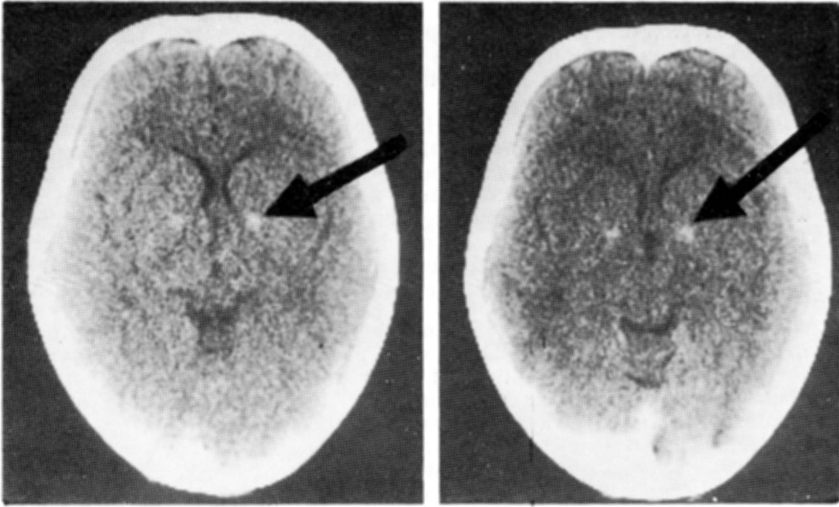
Case AO. Left: CT scan showing hyperdensity in the putamina. Right; axial contrast-enhanced CT shows no enhancement of putamina hyperdensity.
